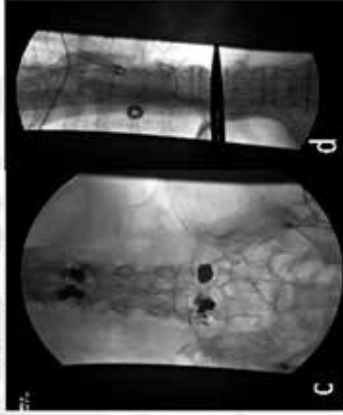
CT Fluoroscopy demonstrating bilateral L2, L5 kyphoplasty. 61AP Fluoroscopy of intrathecal pump catheter.
